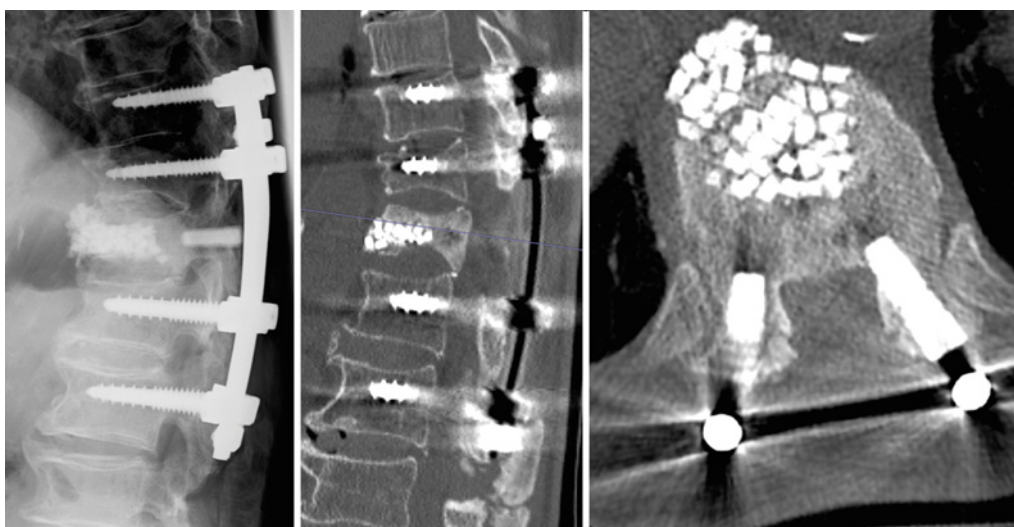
Postoperative X-ray and CT revealed rigid fixation and complete fusion of the bony fragment within the vertebra one year later.
